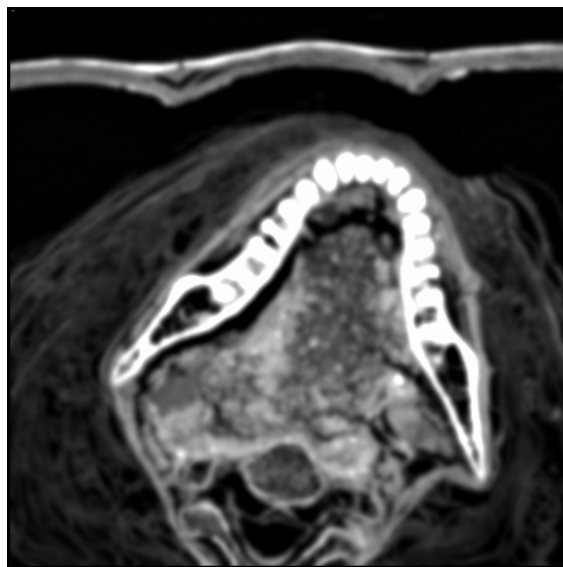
CT through the teeth
